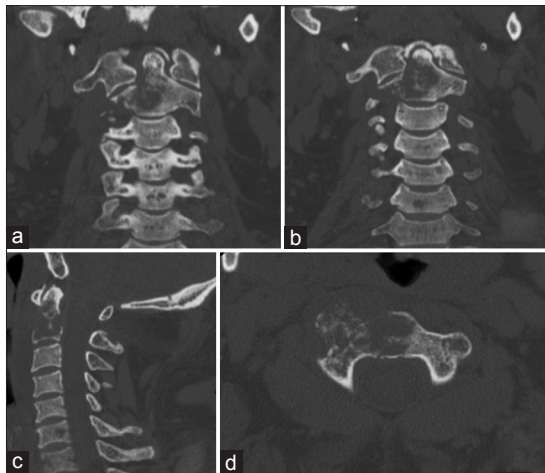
Computed tomography scan cervical spine showing lytic lesion in the body and dens of C2 (a and b) coronal (c) sagittal (d) axial images
